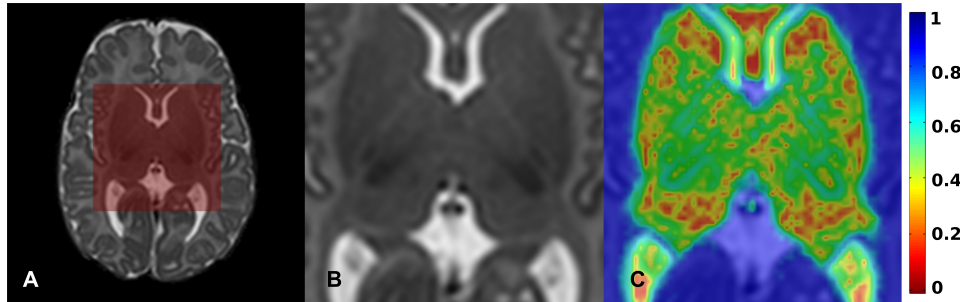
Axial slice of a T2-weighted MRI (A), magnified region of the deep grey matter (B) and the weighting of EM in the model ensemble (C). In red areas the segmentation decision is primarily based on label fusion while in blue areas the result is dominated by the GMM model.
